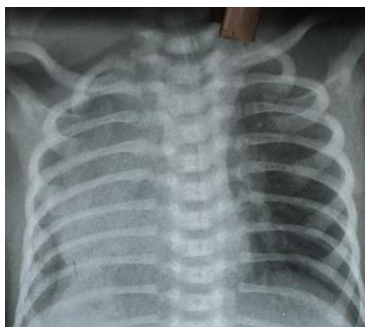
Chest radiographic showing a) small, hypoplastic right lung with ipsilateral cardio-mediastinal shift. b) Faintly visualized curved tubular structure behind the right cardiac border in the shape of a turkish sword was noted. c) The right cardiac border is blurred
